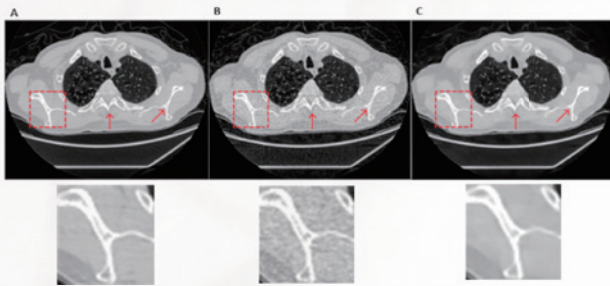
Restoring chest CT image with the specific zoomed regions within the red box²³. A) normal dose image, B) low-dose image, C) CNN-processed image
